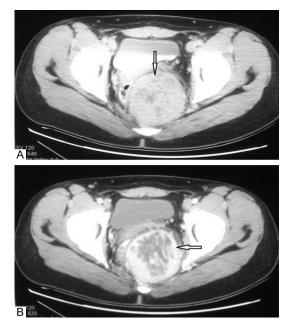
A. Computed tomography (CT) examination revealed a mass lesion, 8.1 cm in diameter, located in the left posterior wall of the pelvic cavity (arrow). B. On contrast-enhanced CT, the lesion had significant heterogeneous density during the arterial phase (arrow).
